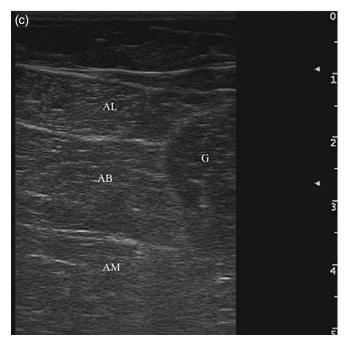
Hip adduction spasm. (a) The adductor muscles. (b) Position of probe for transverse ultrasound image of the anterior and medial surface of the left thigh. (c) Ultrasound image showing the adductor longus (AL), adductor brevis (AB), adductor magnus (AM) and gracilis (G) muscles.
